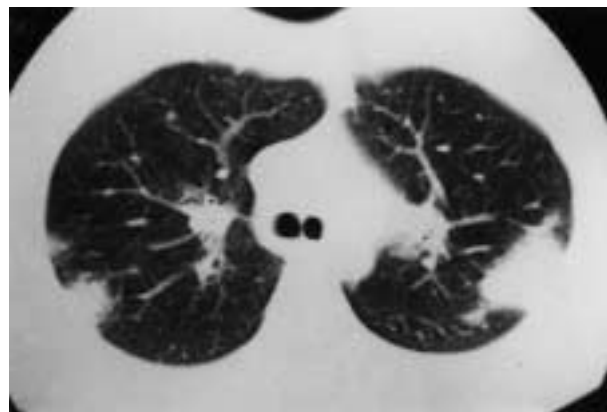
Patchy alveolar opacities typical of bronchiolitis obliterans organizing pneumonia (BOOP) on computed tomography (CT) scan.
